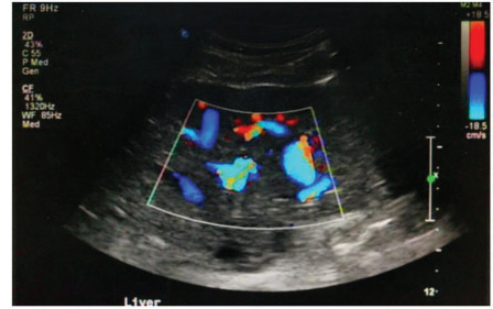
Transabdominal ultrasound examinations of a 43-year-old female patient, gravida 2, para 1, at 36 weeks of gestation, admitted in a stable condition following the diagnosis of placenta accreta for 1 month, revealed diffuse hepatic artery dilatation. The colour version of this figure is available at: <http://imr.sagepub.com>.
